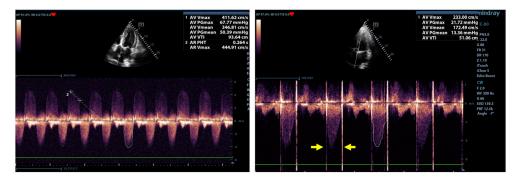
b.11. MPG of 50 mmHg and  $V_{mx}$ =4,11 m/s indicating severe aortic stenosis (left; CW Doppler, parasternal 5-chambers view) and normal MPG of 13 mmHg after aortic replacement with prosthetic valve (arrows shows opening and closing of the prosthesis' metallic disks) (right; CW Doppler, parasternal 5-chambers view)
